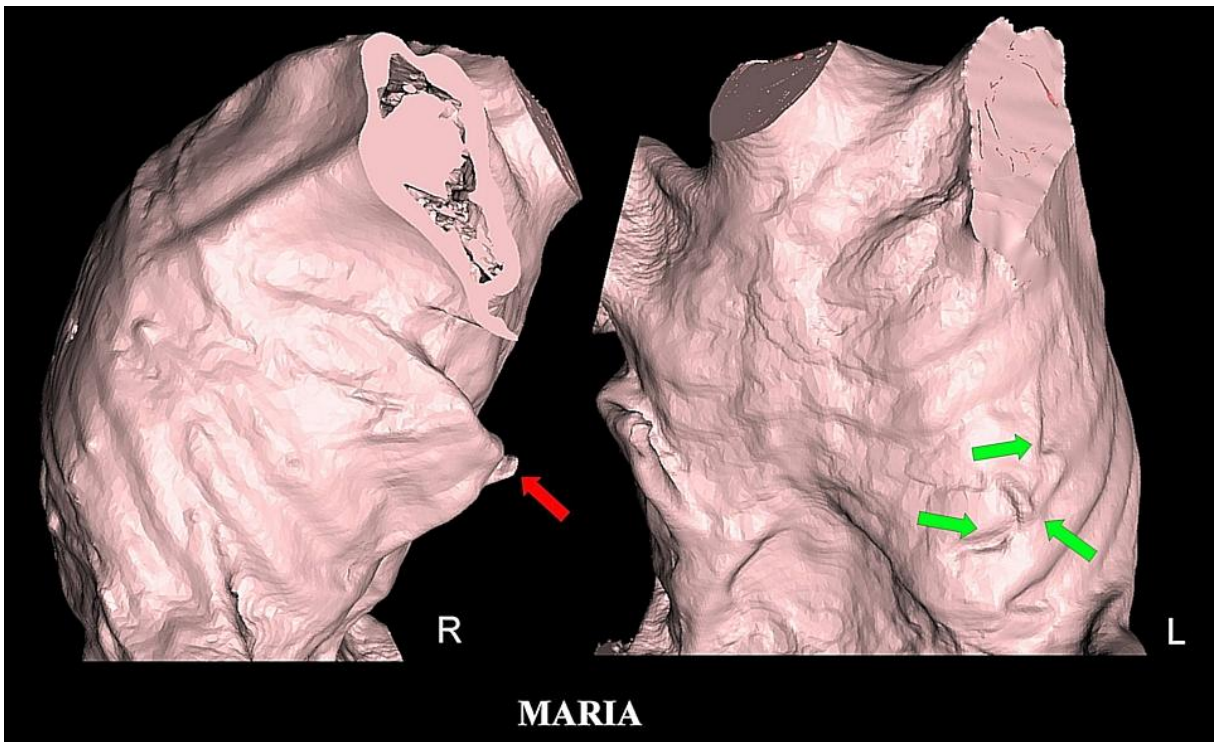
3D CT showing flattened well developed right breast (*left image*) with nipple (*red arrow*). The left breast (*right image*) was not found and replaced by linear raised edges (*green arrows*) suggestive of surgical scars.
